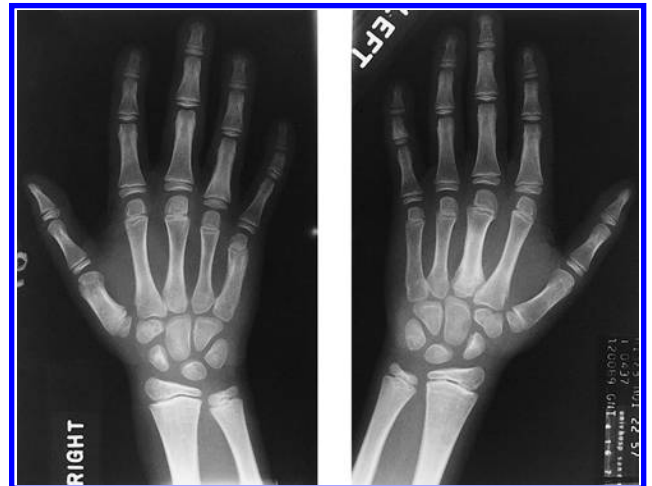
Roentgenogram of the hands of the same 16-year-old looks normal. This highlights the difference in the bones of this disease, from those of disorders with more severe dysostosis multiplex.
